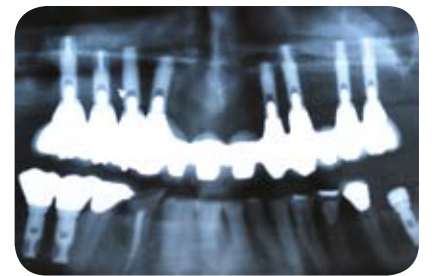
Panoramic radiograph of completed treatment
